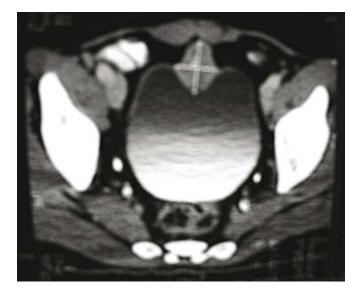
A CT scan shows a solitary urachal tumor apparently confined to the bladder wall (about 3 cm diameter)
